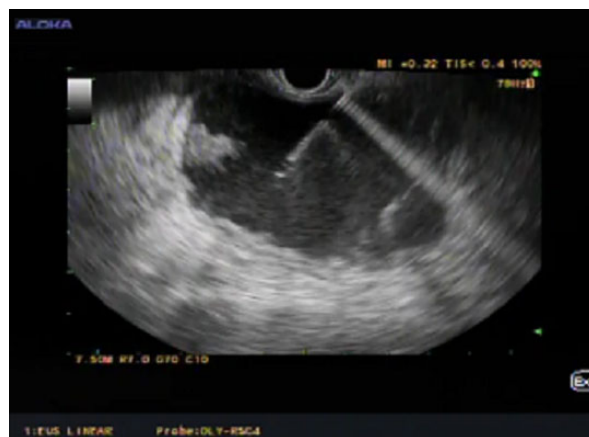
Pseudocyst punctured by a 19 G needle under endoscopic ultrasound guidance.
